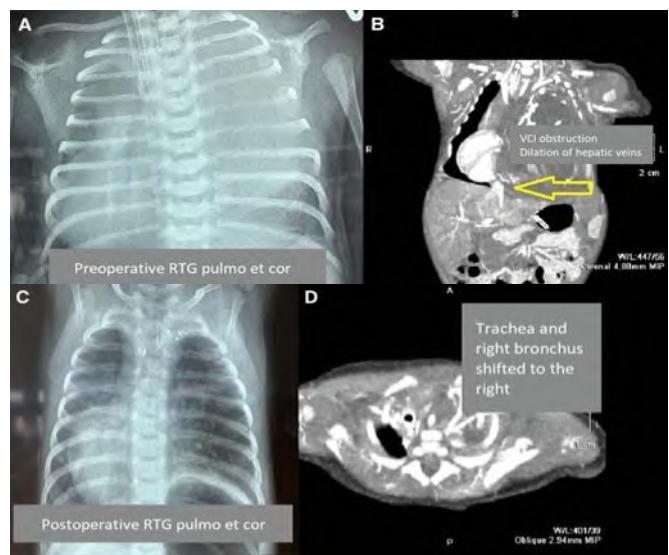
(A) Preoperative chest X-ray, (B) Chest CT showing obstruction of the inferior vena cava (IVC), (C) Postoperative chest X-ray, (D) Chest CT showing displacement of the trachea and right bronchus to the right.
